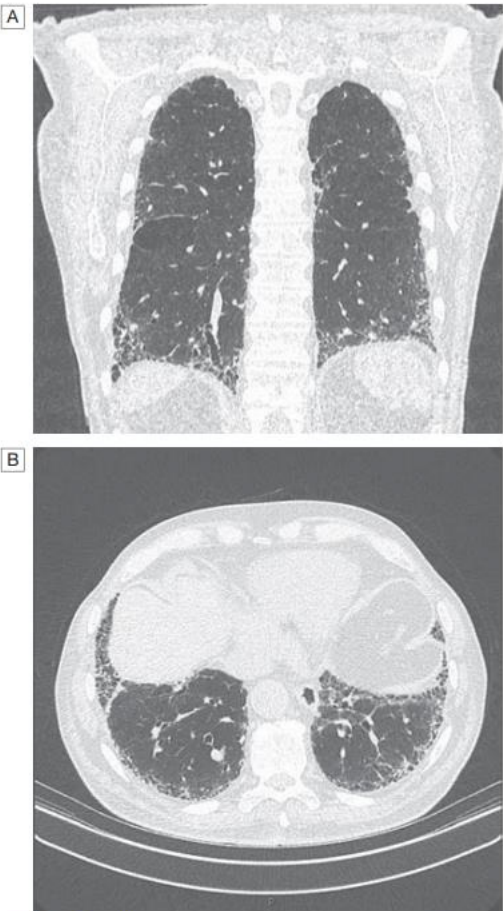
Idiopathic pulmonary fibrosis. Typical high-resolution CT images demonstrate the bilateral, predominantly basal and peripheral reticular opacities, accompanied by honeycombing in the later stages. [A] Anteroposterior view. [B] Transverse section. Courtesy of Dr Andrew Baird, Consultant Radiologist, NHS Lothian, Edinburgh, UK.
